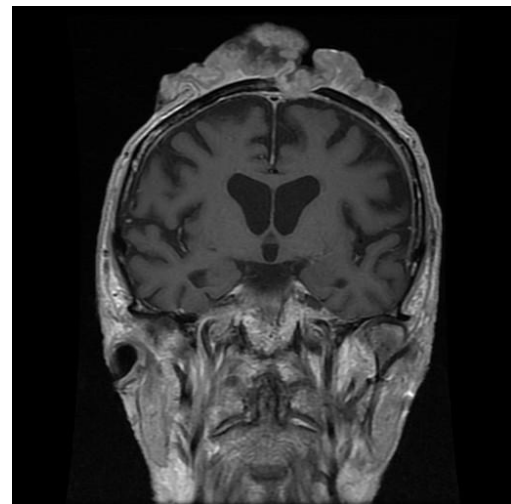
MRI demonstrating penetration of the skull and impression of the sagittal sinus
